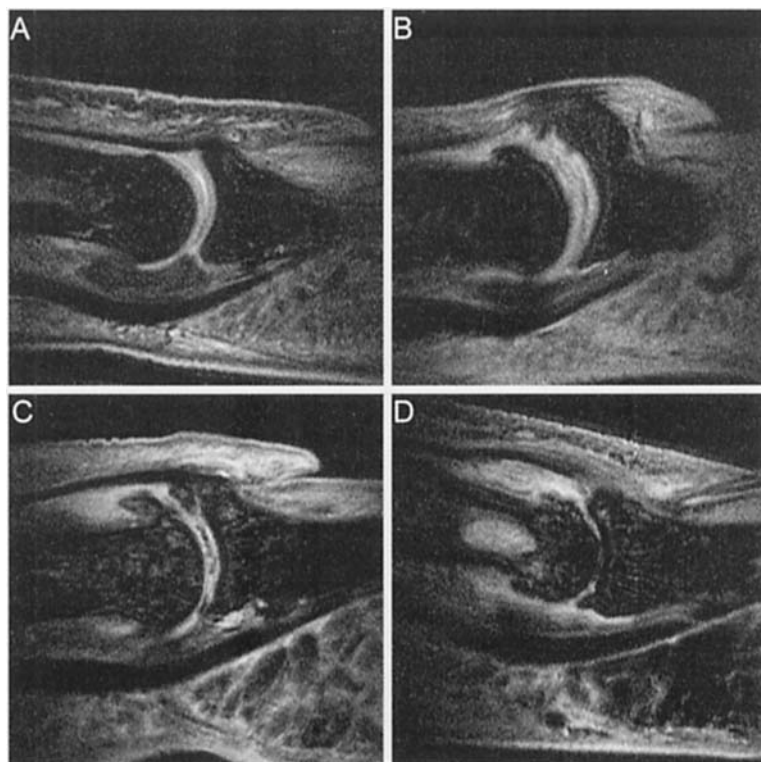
Spin echo, fat suppressed MR images showing a sagittal view of the same joints described in Figure 1.
